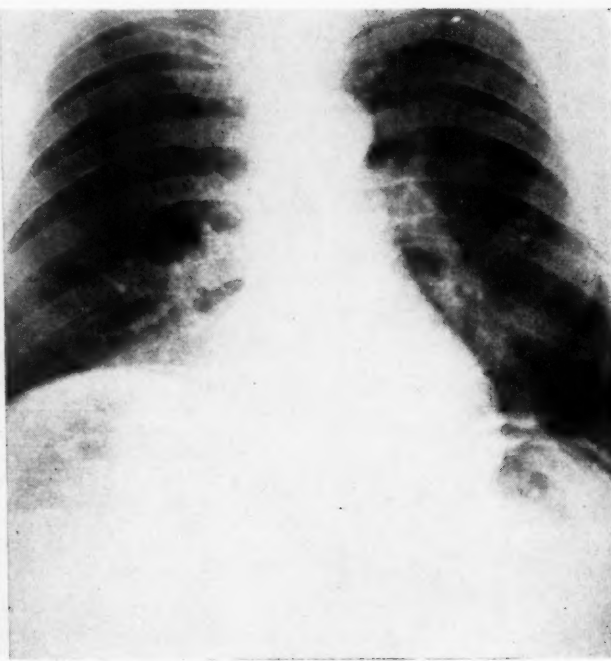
Roentgenogram taken on December 21, 1945, shows free air under both leaves of the diaphragm.
